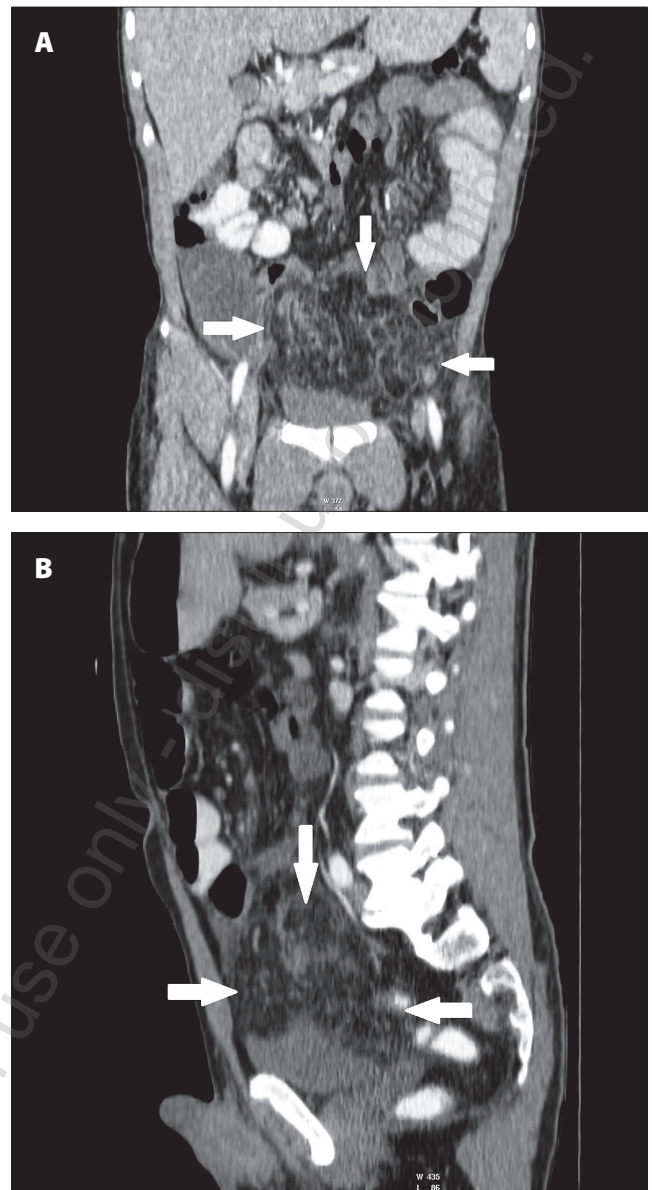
(A) (B). CT + CM in arterial phase. MPR reconstructions. Pathological tissue mass with predominance of adipose tissue in the abdomen exerting pressure on the top and front of the bladder
